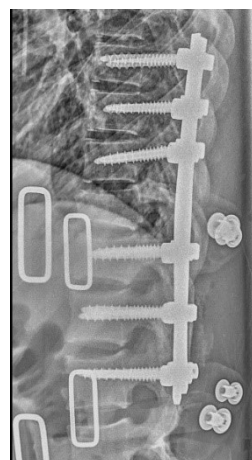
Post-operative x-ray showing lateral view with restored alignment and height of the fracture segments
